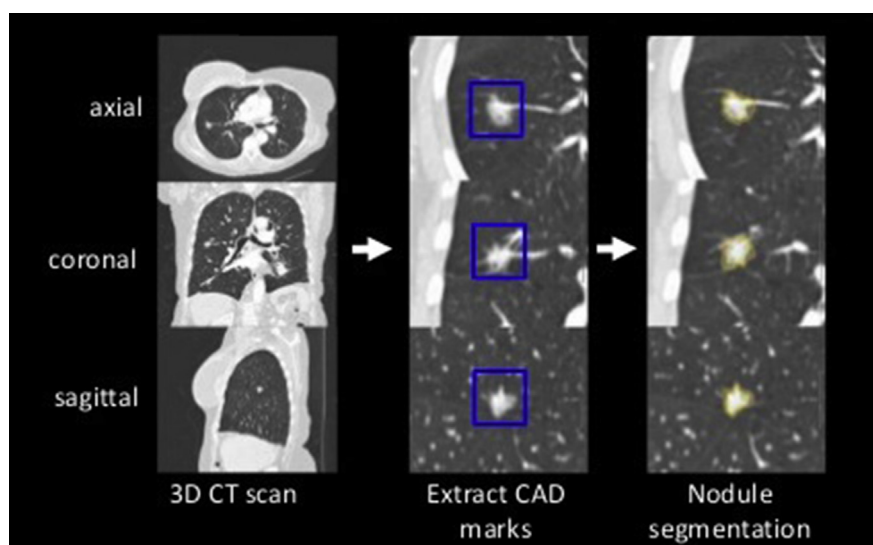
CAD System. Chest CT images with CAD markings of a lung nodule. (Permission from Arnaud Setio).
